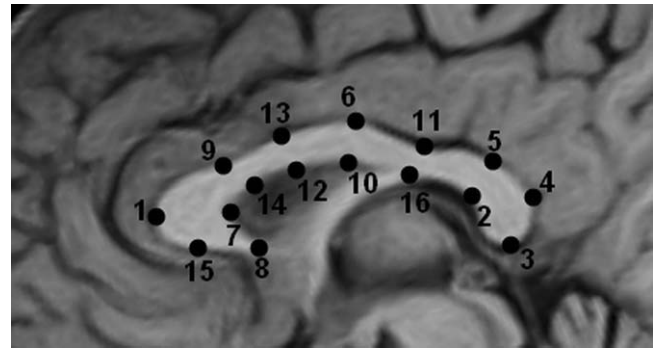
T1-weighted midsagittal slice demonstrating the CC landmarks.
